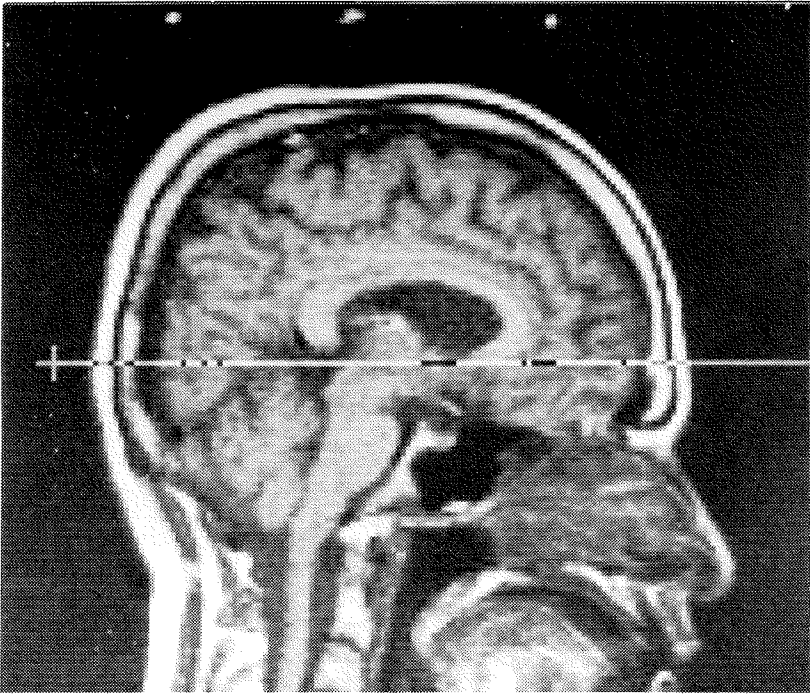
Mid-sagittal MR scan with patient in stereotactic frame. The horizontal line marks the plane of the anterior and posterior commissures and locates the position of the axial image seen in MRI.
